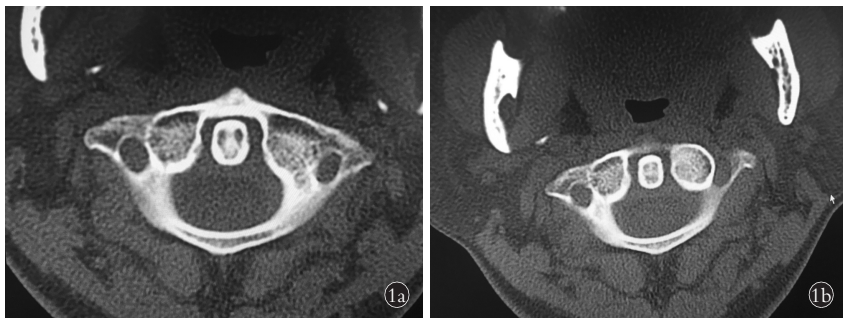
女性患者，47 岁，外伤致寰枢椎关节半脱位 1a. 治疗前 CT 示寰枢椎间隙不对称，右侧约 2 mm，左侧约 3 mm 1b. 经过 1 个疗程的牵引治疗后复查 CT 示寰枢椎间隙左右对称，疼痛缓解，活动自如
